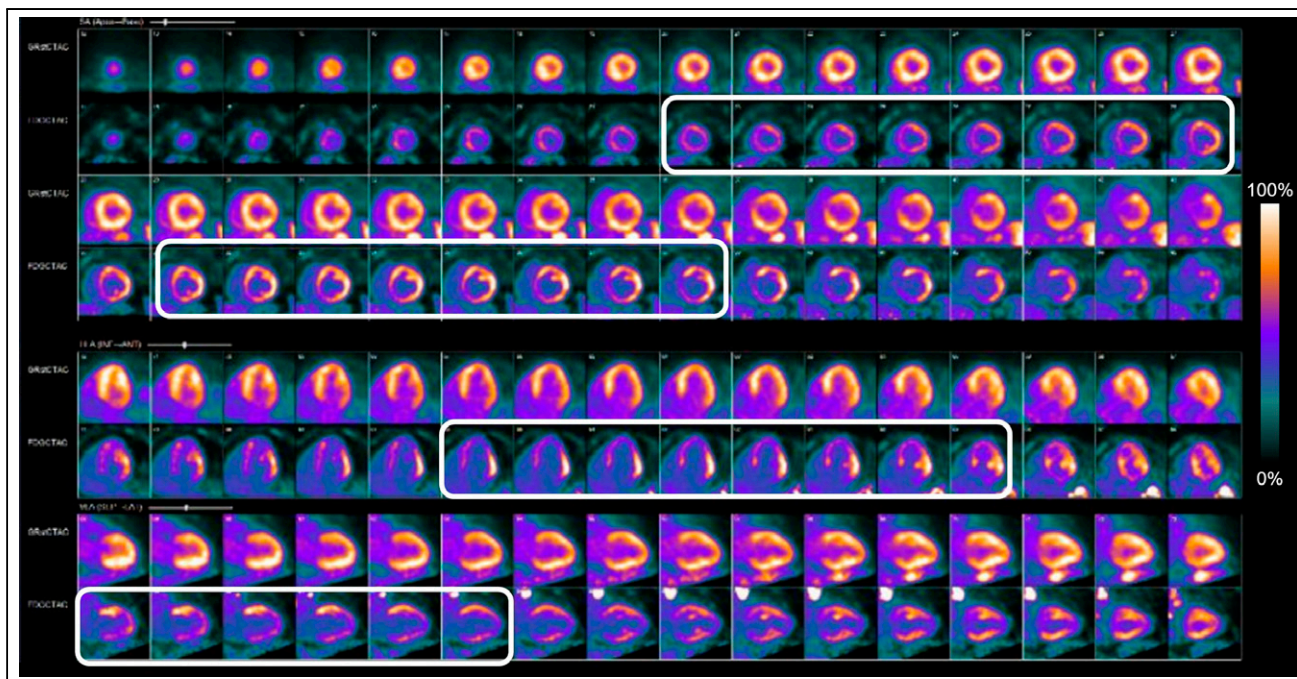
Scan 3 ^{82}Rb -chloride rest perfusion (top rows) and ^{18}F -FDG cardiac metabolism (bottom rows). Rest MPI shows no significant perfusion defects in LV. ^{18}F -FDG PET images show diffusely increased myocardial uptake (rectangles), more prominent in lateral wall. This pattern of diffusely increased ^{18}F -FDG cardiac uptake indicates hyperinsulinemic state, suggesting possible inadequate dietary compliance, and limits evaluation of ^{18}F -FDG-PET images for cardiac sarcoidosis. Gated rest images show estimated LVEF of 24%.
